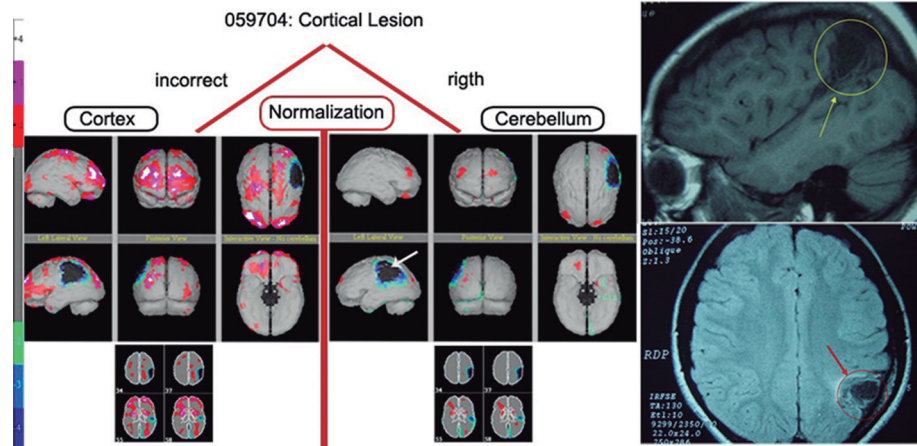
MRI and normalization types of case 1.
